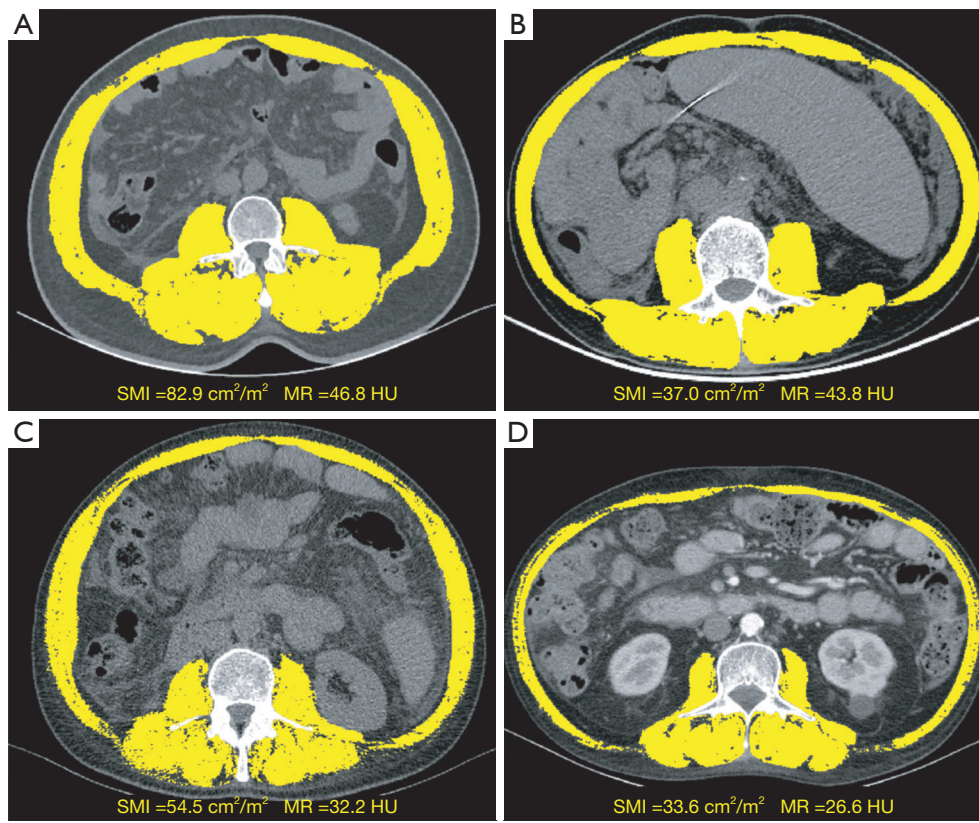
Typical CT images of muscle changes. (A) Patients without muscle changes; (B) patients with isolated sarcopenia; (C) patients with isolated myosteatorsis; (D) patients with combined sarcopenia and myosteatorsis. SMI, skeletal muscle index; MR, muscle radiodensity; CT, computed tomography; HU, Housefield unit.
